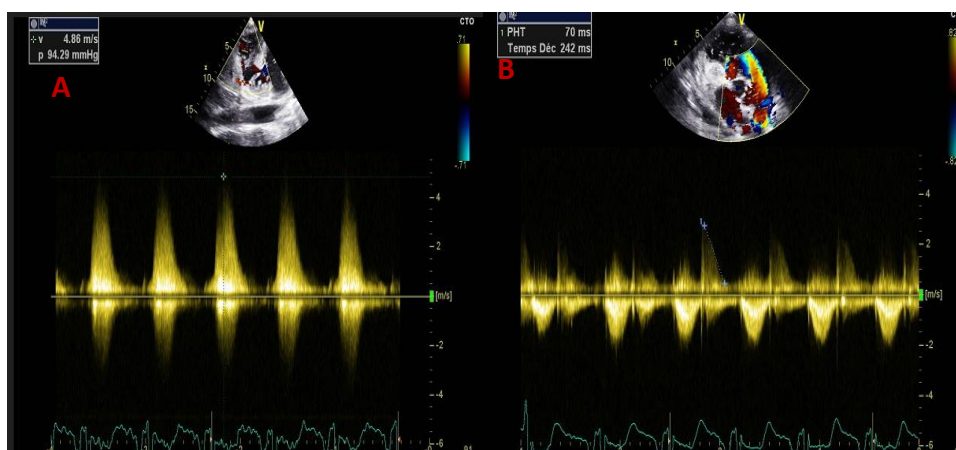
A and B. Color doppler and Continuous wave doppler : Gradient a trans Ventricular septal defect of 94mmHg and a PHT value of 70ms
